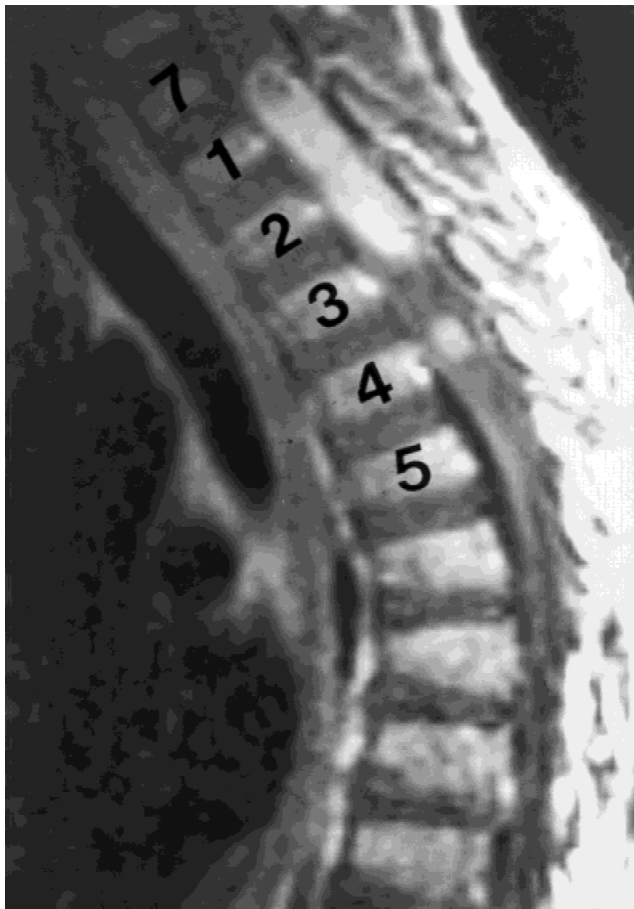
MRI, performed March 5, 1997, showing tumor at the cervical thoracic junction. Vertebral bodies are numbered.
